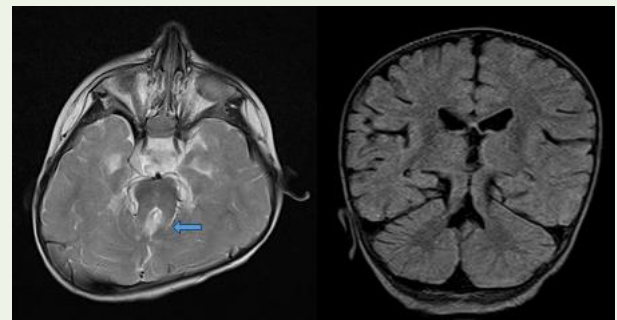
Axial T2W (a) and COR FLAIR (b) image shows thick and elongated superior cerebellar peduncles (blue arrow) imparting molar tooth appearance and aplasia of the cerebellar vermis. Bilateral cerebellar hemispheres appear normal.
